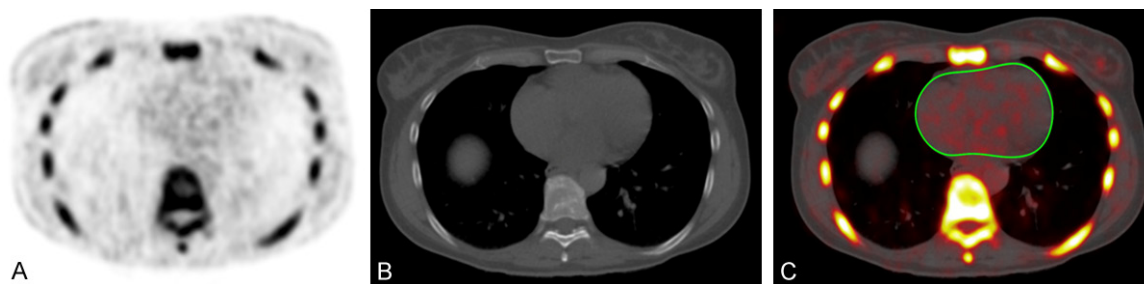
Axial view NaF-PET (A), CT (B), and fused NaF-PET/CT (C) images with region of interest in an at-risk subject (C). The manually-delineated region of interest determined the global coronary artery NaF uptake and did not include uptake from the aortic valve, skeletal structures, and aortic wall.
